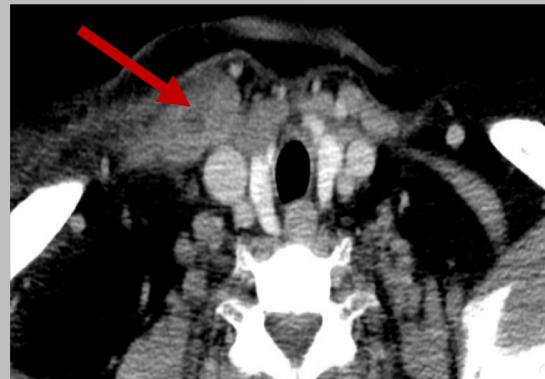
CT Neck with Contrast: Septic arthritis involving the right sternomanubrial joint with associated myositis involving the right sternocleidomastoid, right sternohyoid and partially visualized right pectoralis muscles.
